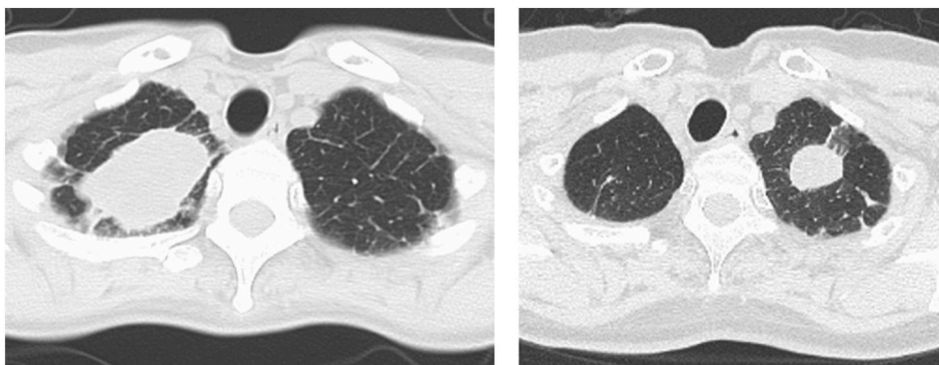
(A) Chest computed tomography (CT) revealed a mass lesion of 50 mm in the apical portion of the right lung. (B) Four years after the lobectomy, another nodule of 20 mm appeared in the apical portion of the left lung.
